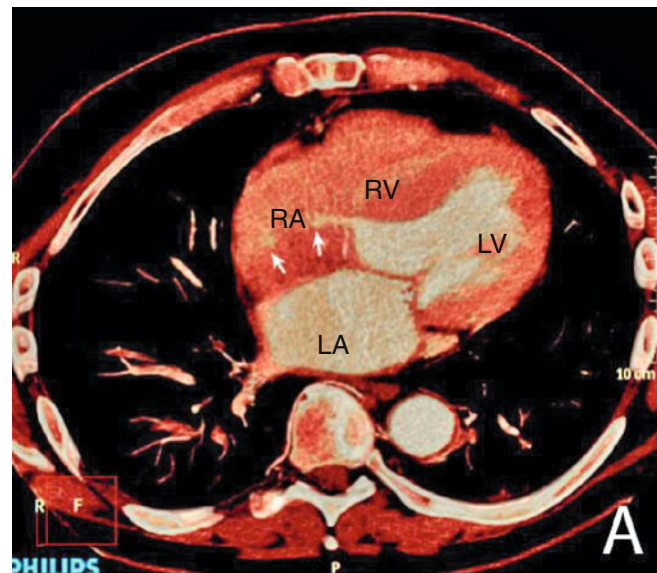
A color computed tomographic image demonstrating a Gerbode-type ventricular septal defect (VSD). Here, the defect resides in the membranous septum separating left ventricle and right atrium (atrioventricular septum) (Reproduced from Dragicevic et al. [35]. With permission of Leelakrishna Nallamshetty, MD, Department of Radiology, University of South Florida, Tampa General Hospital)
